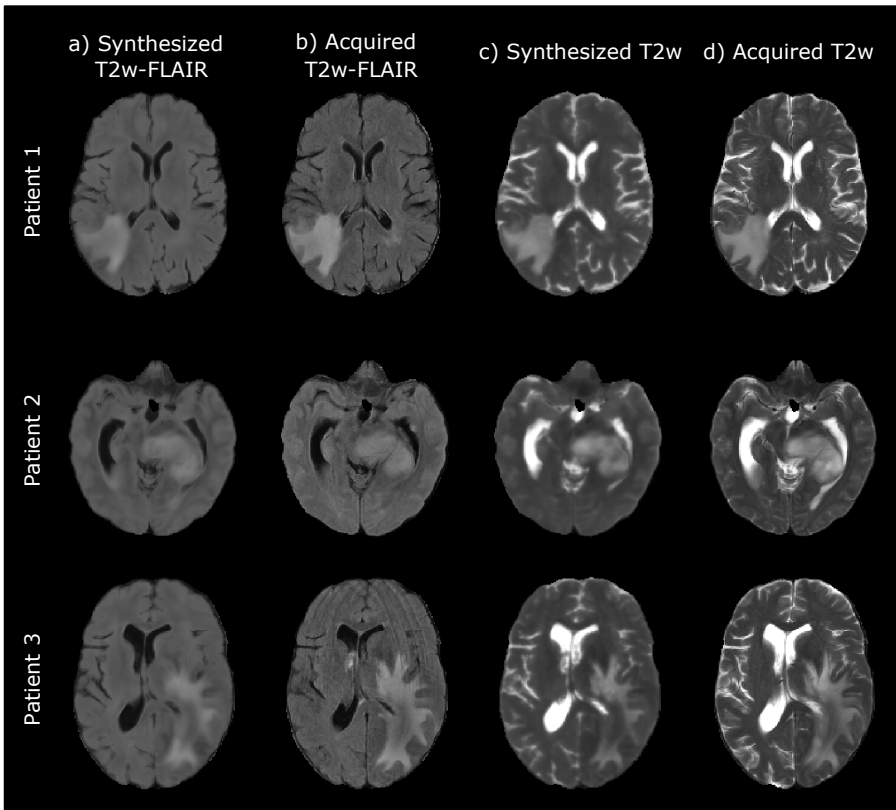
A representative axial slice of the synthesized images by the self-supervised CNN for different test patients of *Multicontrast Glioblastoma*. a) Synthesized T2w-FLAIR images. b) Corresponding actually acquired T2w-FLAIR images. c) Synthesized T2w images. d) Corresponding actually acquired T2w images.
